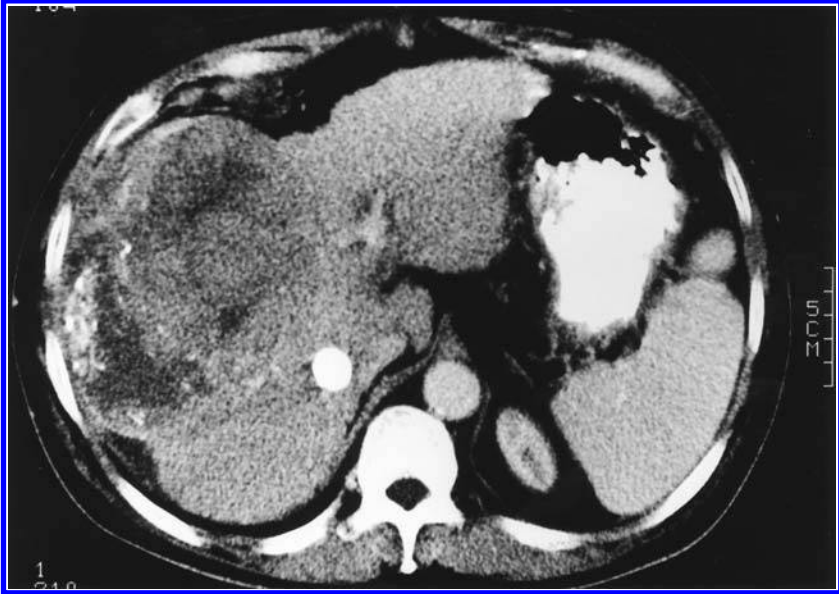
CT scan 1 month following embolization showing areas of necrosis. The radiopaque material is residual ethiodol from the chemoembolization.
